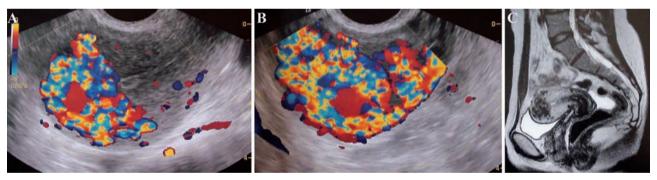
A and B: Transvaginal ultrasound with color Doppler showing hypervascular areas with turbulent flow at the uterine fundus. C: Pelvic MRI showing the AVF at the uterine fundus.
